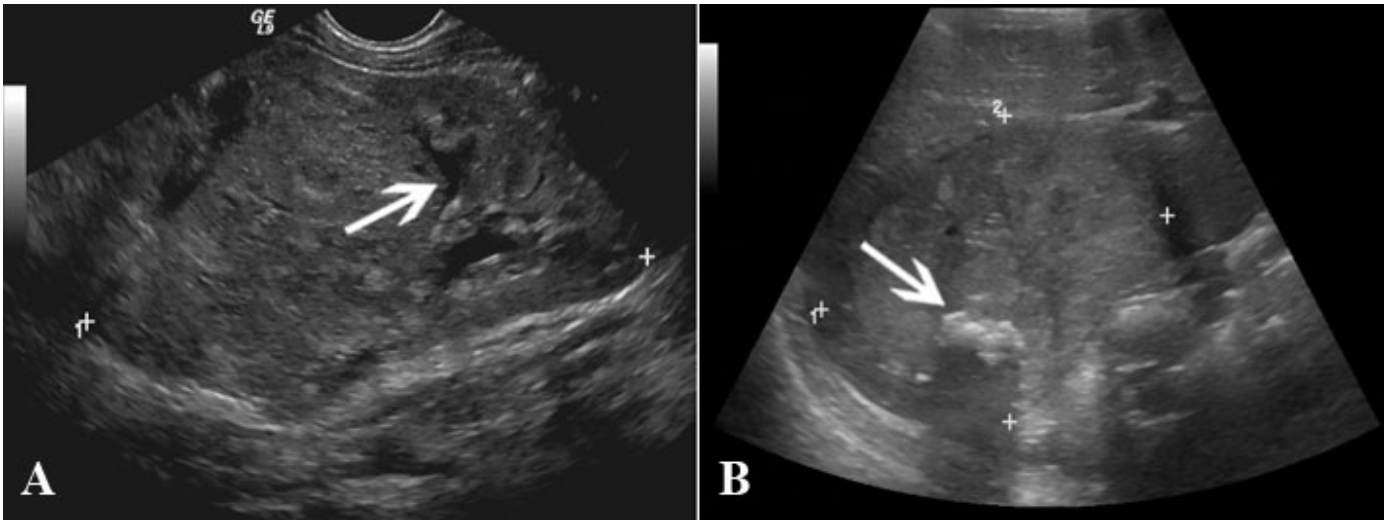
Ultrasound surveillance in BWS. (A) Typical appearance of Wilms tumor as intrarenal mass with "claw sign" (arrow) formed by interface with normal renal parenchyma. (B) Typical appearance of hepatoblastoma as intrahepatic mass with dense calcifications.
